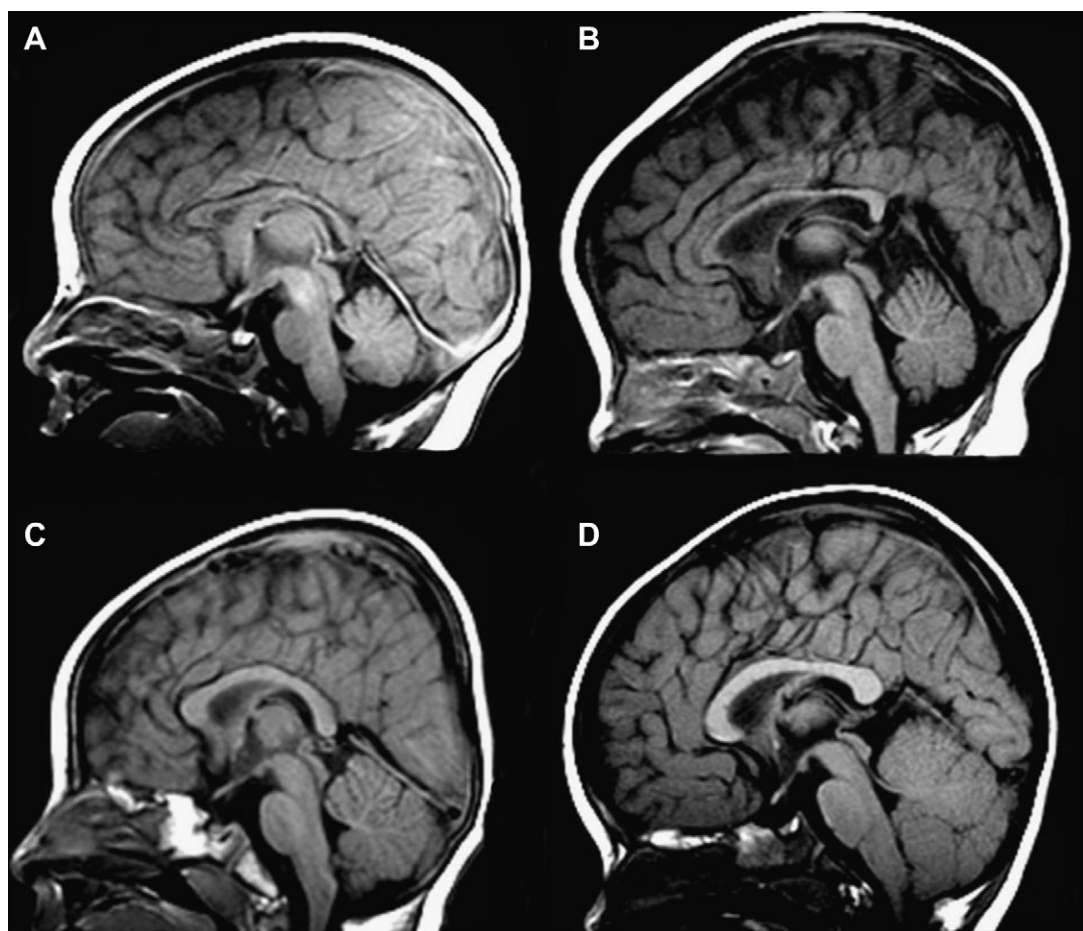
Imaging of myelination. Sagittal T1-weighted sequences demonstrating normal development of the corpus callosum. (A) term, (B) 4 months, (C) 6 months, and (D) 16 months.
